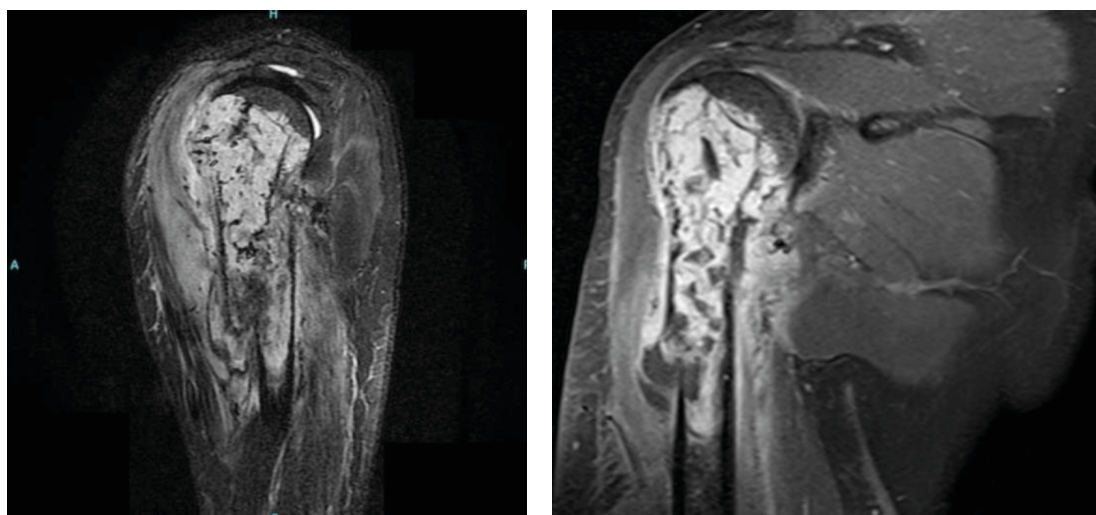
MRI examination of the shoulder showed an expansive lesion of the proximal humeral, with infiltration of the adjacent soft tissues, including the triceps and deltoid
